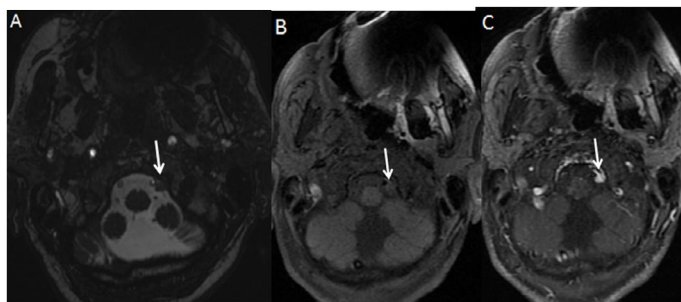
Axial Fiesta (A) and T1-weighted (B) images at foramen magnum level show a lesion (arrow) adjacent to the left hypoglossal canal and vertebral artery. Axial contrast-enhanced T1-weighted image (C) demonstrates homogeneously enhancing lesion (arrow) with dural tail
